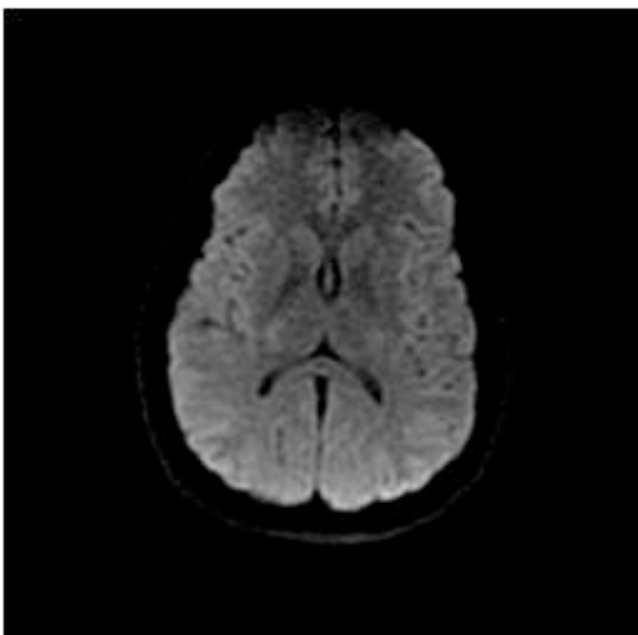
Initial MRI (DWI sequence) showing no cerebral infarct.
